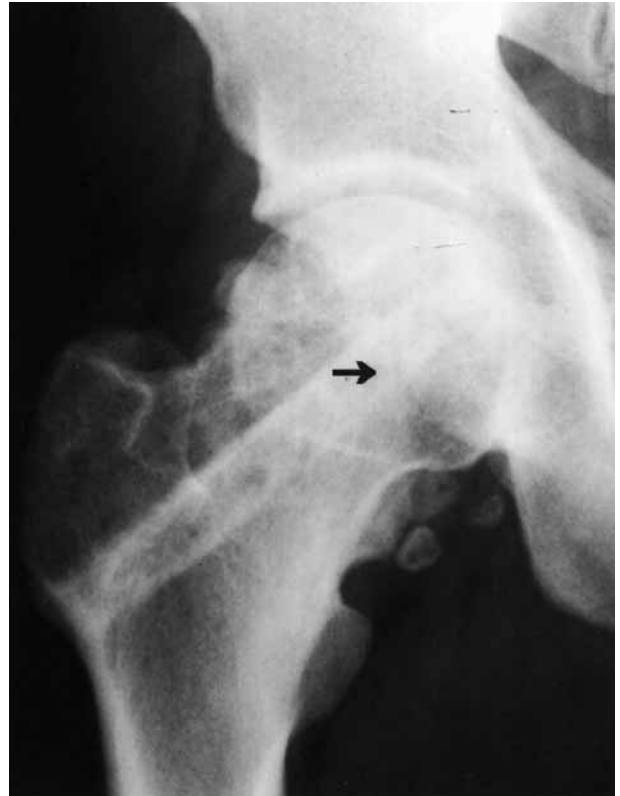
Radiograph of hip (AP view) showing almost complete retention of the fibular graft outline 5 years post surgery, with good union and trabeculae crossing the fibular graft (arrow).
